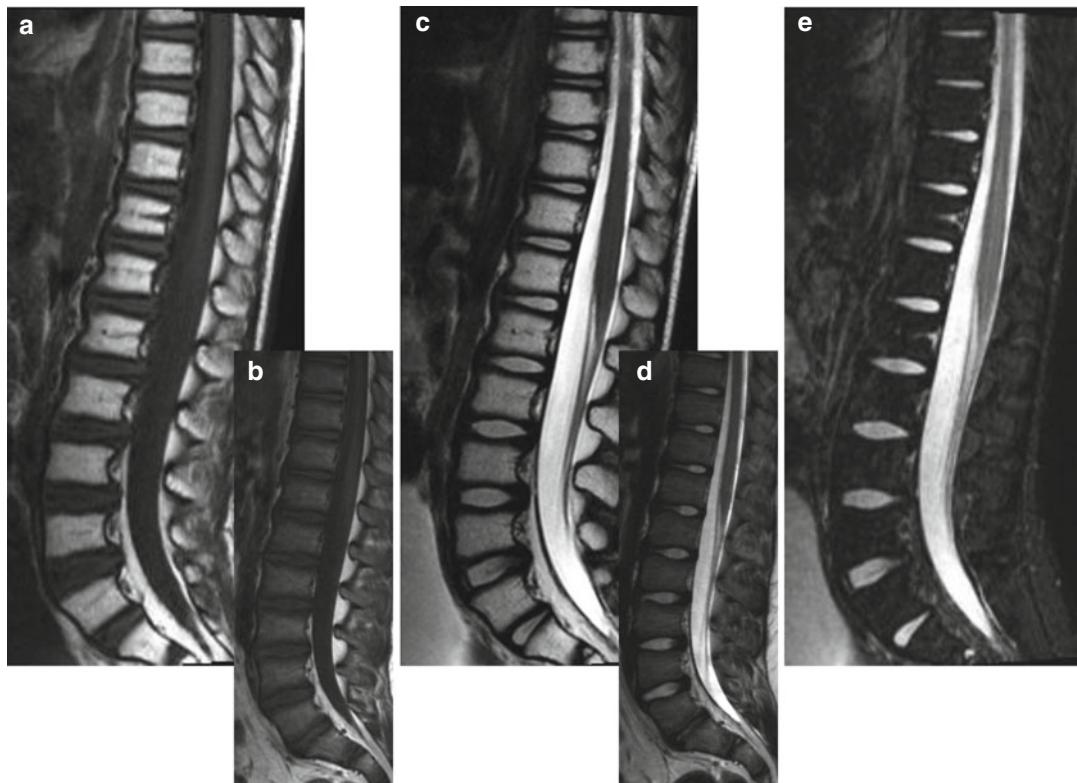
Diffuse fatty marrow radiation-induced conversion. Mid-sagittal T1-WI (a), T2-WI (c) and STIR (e) of a children who underwent whole spine radiation therapy (photon therapy or standard X-ray radiation therapy)
